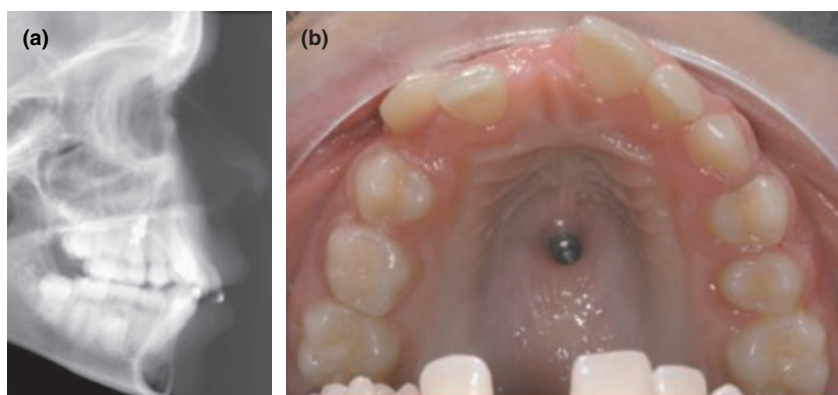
(a) The cephalometric radiograph shows the condition after surgical insertion of an orthodontic anchoring implant (palatal implant; diameter: 3.3 mm; length: 4.2 mm, Orthosystem, Straumann, Switzerland). (b) Intraoral photograph of the upper jaw after surgical insertion of the palatal implant during the 12-week healing time.
